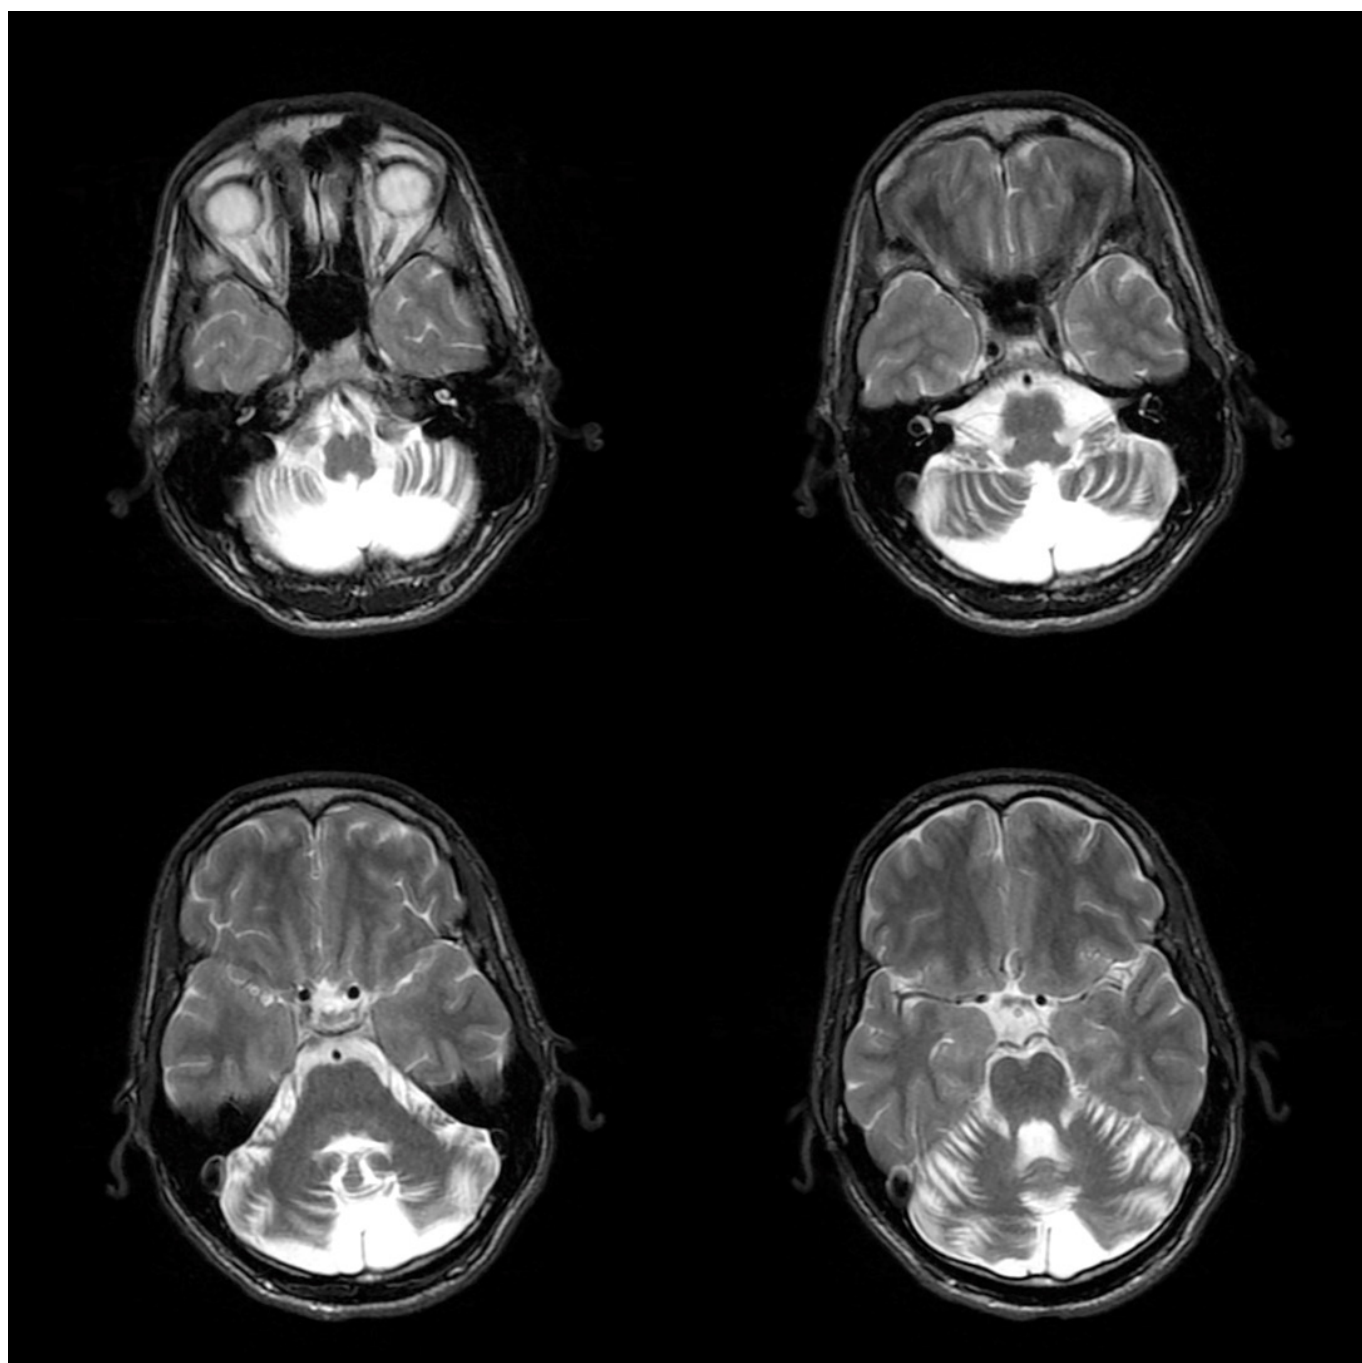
Axial T2 weighted cerebral MRI revealing severe cerebellar atrophy
